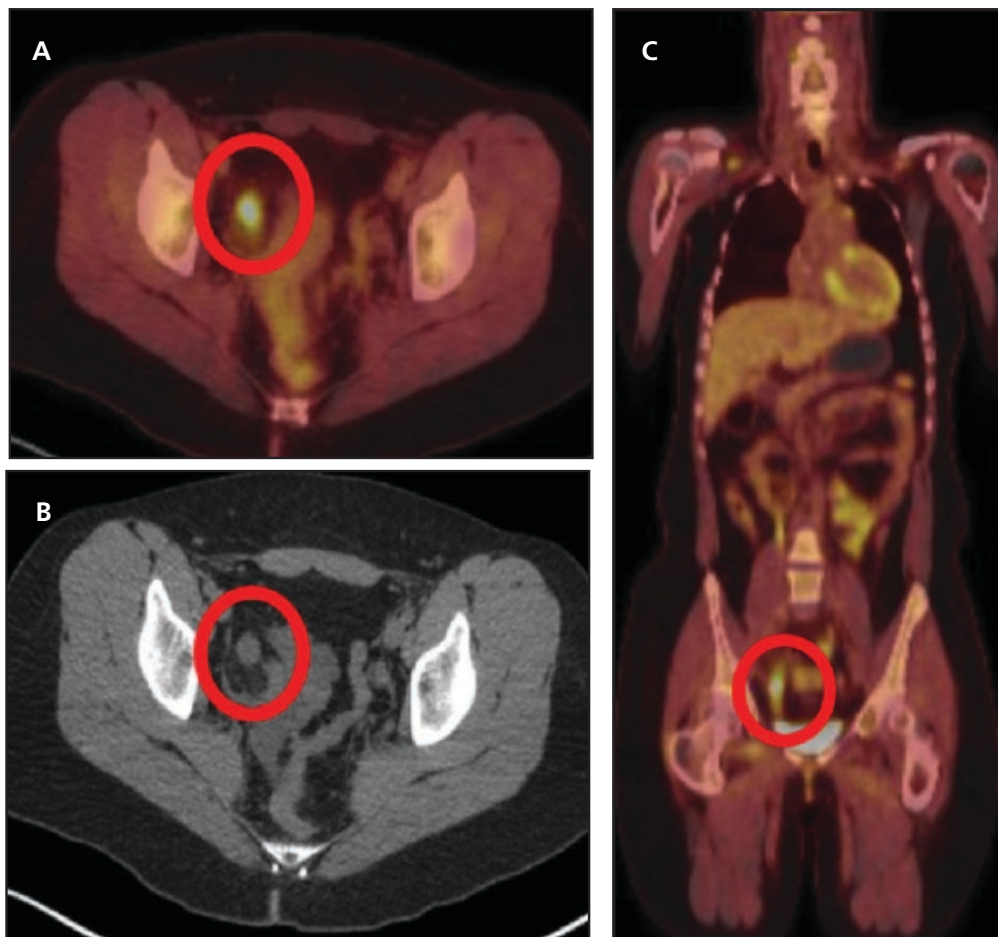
Axial and coronal fused PET-CT images (A, C) show a focal region of hypermetabolic activity within the right lower quadrant (encircled). Corresponding unenhanced axial CT image (B) reveals a dilated appendix with no luminal air and mild adjacent fat stranding (encircled).
